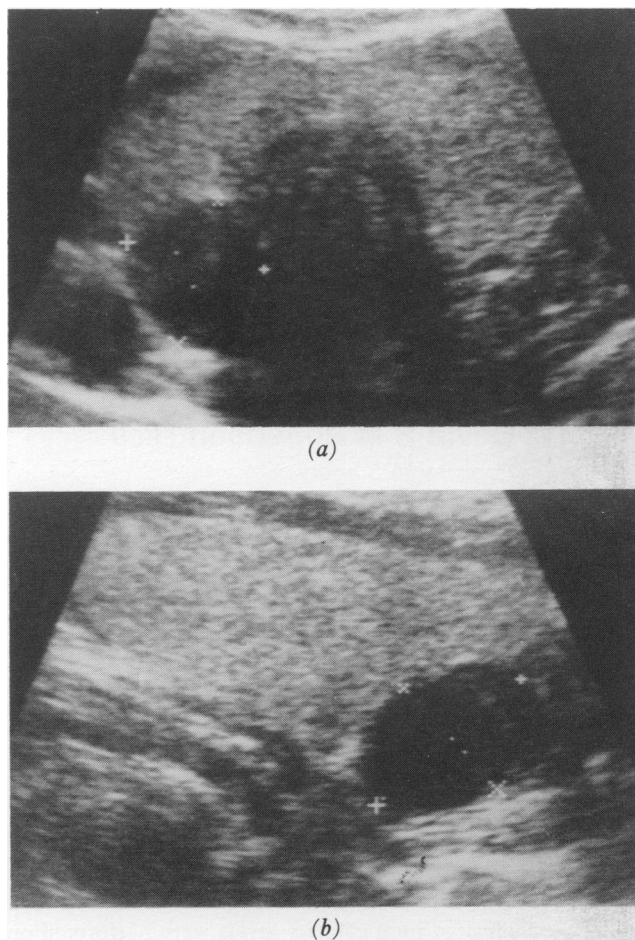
Ultrasound scan of a $2.0 \times 1.5 \times 1.6$ cm parathyroid adenoma in (a) transverse and (b) longitudinal section.
